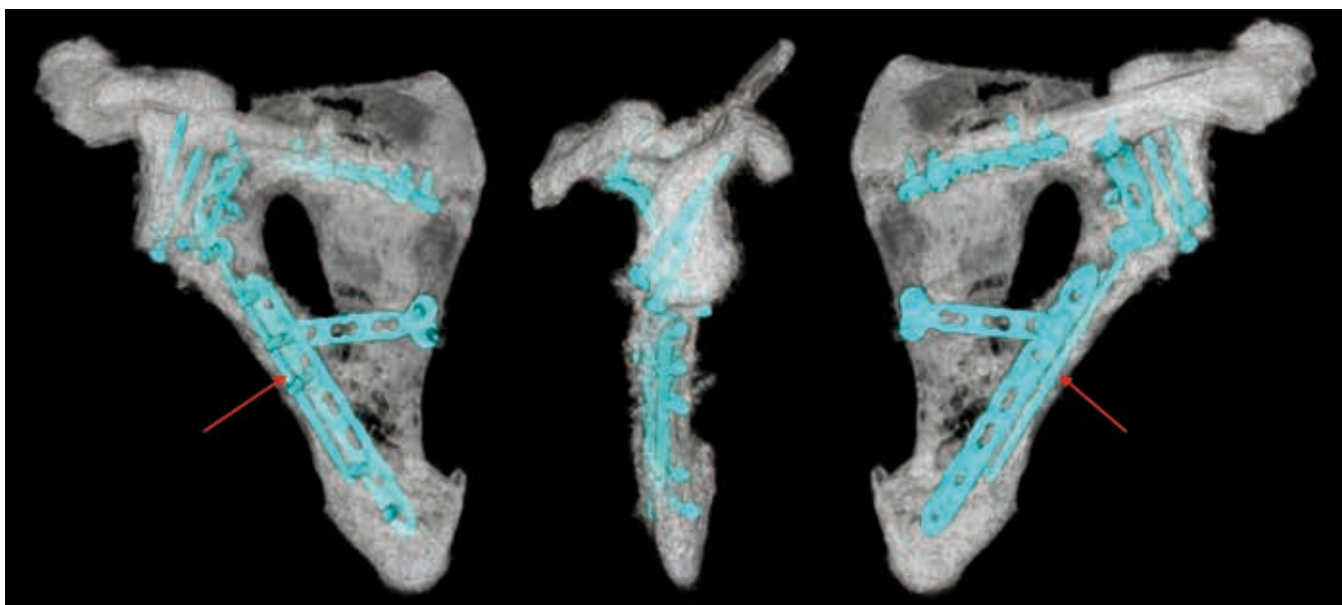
Position of implants on 3D CT reconstructions 2.5 years postoperatively. Red arrow – the lost K-wire.
